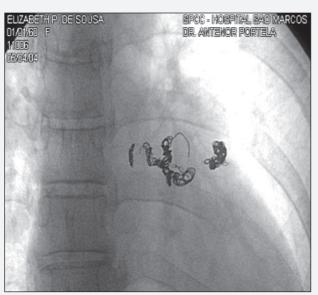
Chest X-ray in ? am PA. Implanted microcoils.
